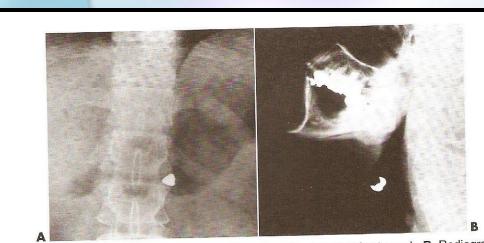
A, Radiograph of swallowed casting in patient's stomach. B, Radiograph of casting lodged in patient's throat.
